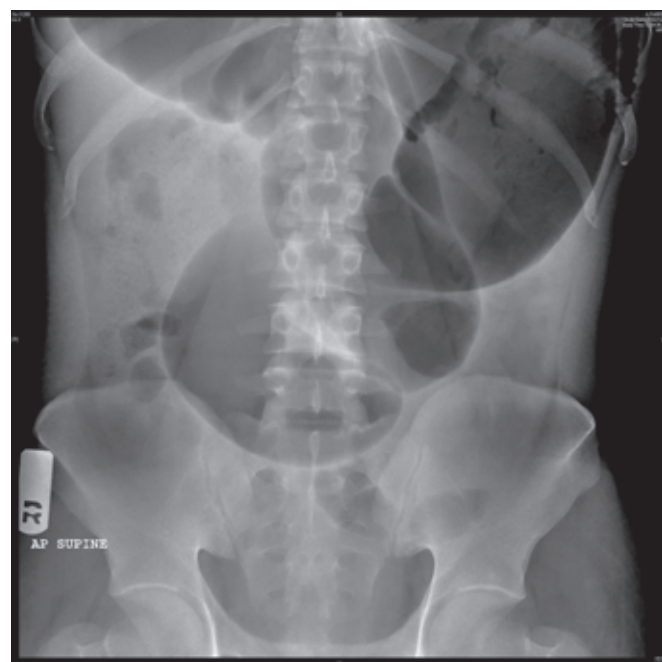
X-ray abdomen showing sigmoid volvulus (case 2)
